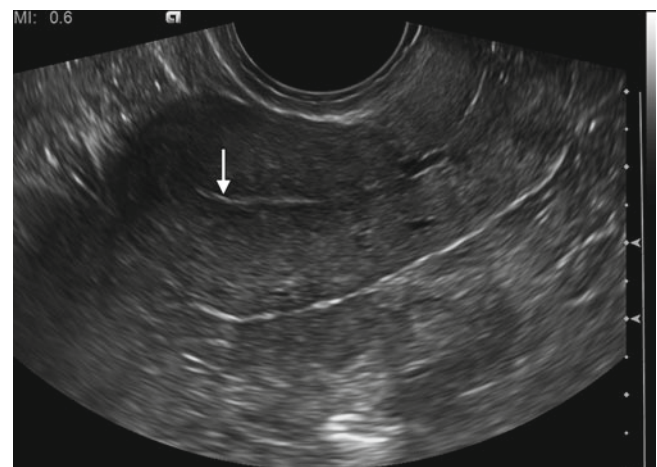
Longitudinal 2-D transvaginal ultrasound image of the normal endometrium (arrow). The hallmark of endometrial cancer on imaging is thickening of the endometrial cavity. Varying size cutoffs have been proposed: the prevalence of endometrial cancer has been reported to be 0.6 % when the endometrial thickness is <5 mm, compared with 19 % when the endometrial thickness is 5 mm or more [5]. However, endometrial thickening may be present in many physiologic and benign conditions
